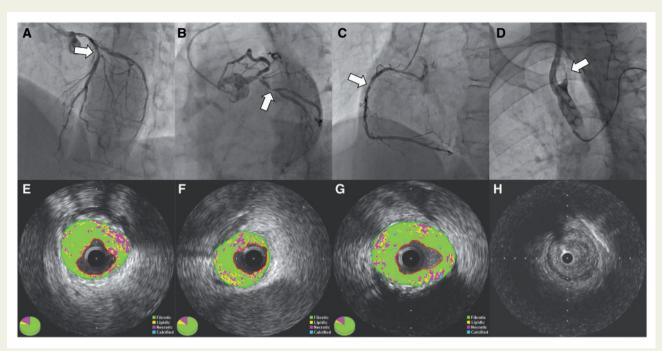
(A) Left anterior oblique cranial view of the left coronary artery shows 75% stenosis in the middle portion of the left anterior descending coronary artery and the diagonal braches. (B) Left anterior oblique caudal view of the left coronary artery shows 99% stenosis in the ostium and 90% stenosis in the middle portion of the left circumflex coronary artery. (C) Left anterior oblique view of the right coronary artery angiogram shows 90% stenosis in the middle portion of the right coronary artery. (D) Brachiocephalic artery angiogram shows 99% stenosis in the proximal segment of the right subclavian artery. (E–G) Characterization of the coronary artery tissues of each cross-sectional segment indicated with the arrows at the top (left anterior descending coronary artery, left circumflex coronary artery, and right coronary artery, respectively) by means of iMap intravascular ultrasound (iMap, 40 MHz, mechanical-type transducer, 3.2 F Atlantis; Boston Scientific Corp., Marlborough, MA, USA; Qlvus analytical software, Medis Medical Imaging Systems bv, Leiden, the Netherlands). Green, fibrotic plaque; yellow, lipidic plaque; pink, necrotic plaque; blue, calcified plaque. (H) A cross-sectional grey-scale intravascular ultrasound image of the stenosis segment in the right subclavian artery (arrow on the top, D). In this case, plaques were fibrotic-dominant plaques.
